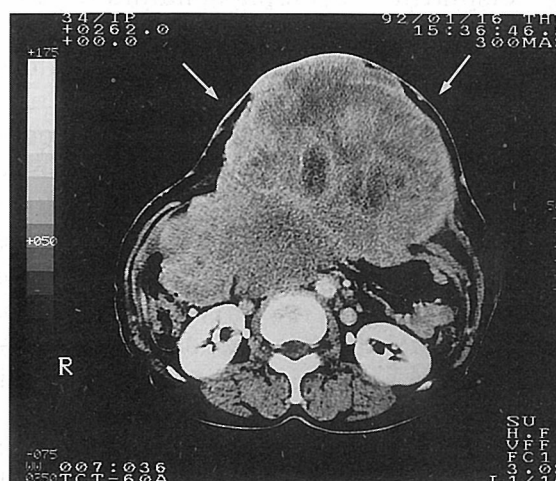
A, 67-year-old woman with malignant schwannoma. Contrast-enhanced CT scan shows the giant subcutaneous tumor (arrow) at the epigastrium.
